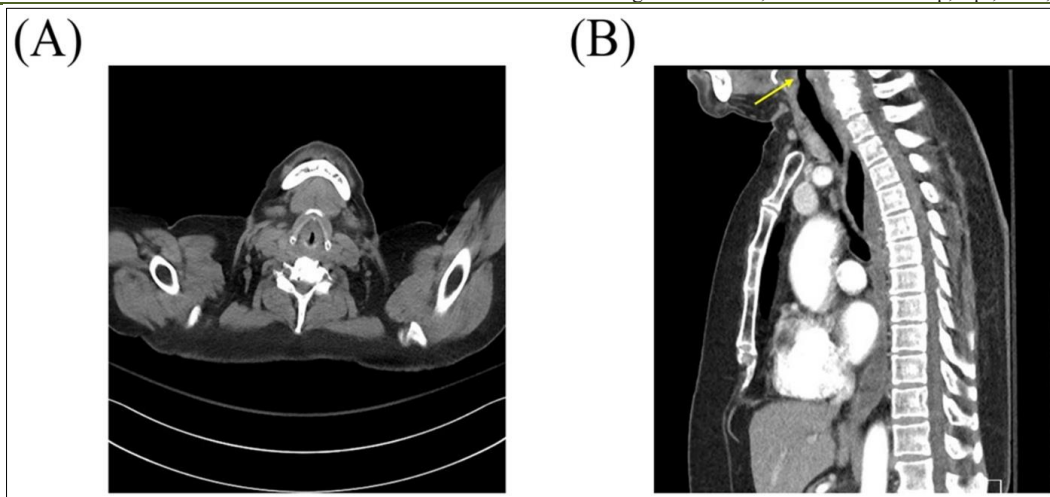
(A) Axial computed tomography (CT) image of the neck showing focal narrowing of the subglottic airway. (B) Sagittal CT image demonstrating significant subglottic stenosis approximately 1.0 cm below the vocal cords (yellow arrow), with the minimal tracheal diameter measuring 4.32 mm
